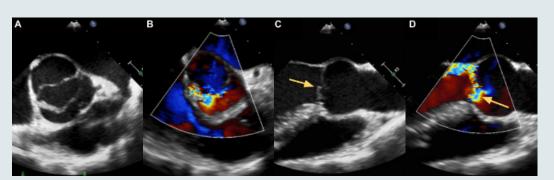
Figure of a patient with a bicuspid aortic valve. Short-axis view of the aortic valve (A) and colour flow doppler demonstrating eccentric AR (B). Also shown the parasternal long-axis view where the prolapse of the cusp is visible as indicated by the yellow arrow (C) along with the eccentric jets (D).
